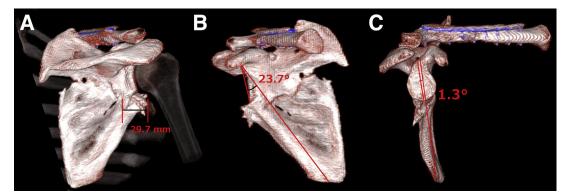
Volume rendering images of a 3-dimensional computed tomographic scan of the right shoulder before arthroscopy. (A) Lateral border offset of 29.7 mm. Lateral displacement is calculated by measuring the distance from the most lateral point of the distal fragment to the most lateral point of the proximal fragment. (B) Glenopolar angle of 23.7°. GPA is measured at the intersection between a line from the inferior glenoid to the superior glenoid and a line from the superior glenoid to the inferior angle of the scapula. (C) Glenoid angulation of 1.3°. Angulation is measured between a line parallel to the proximal fragment.
